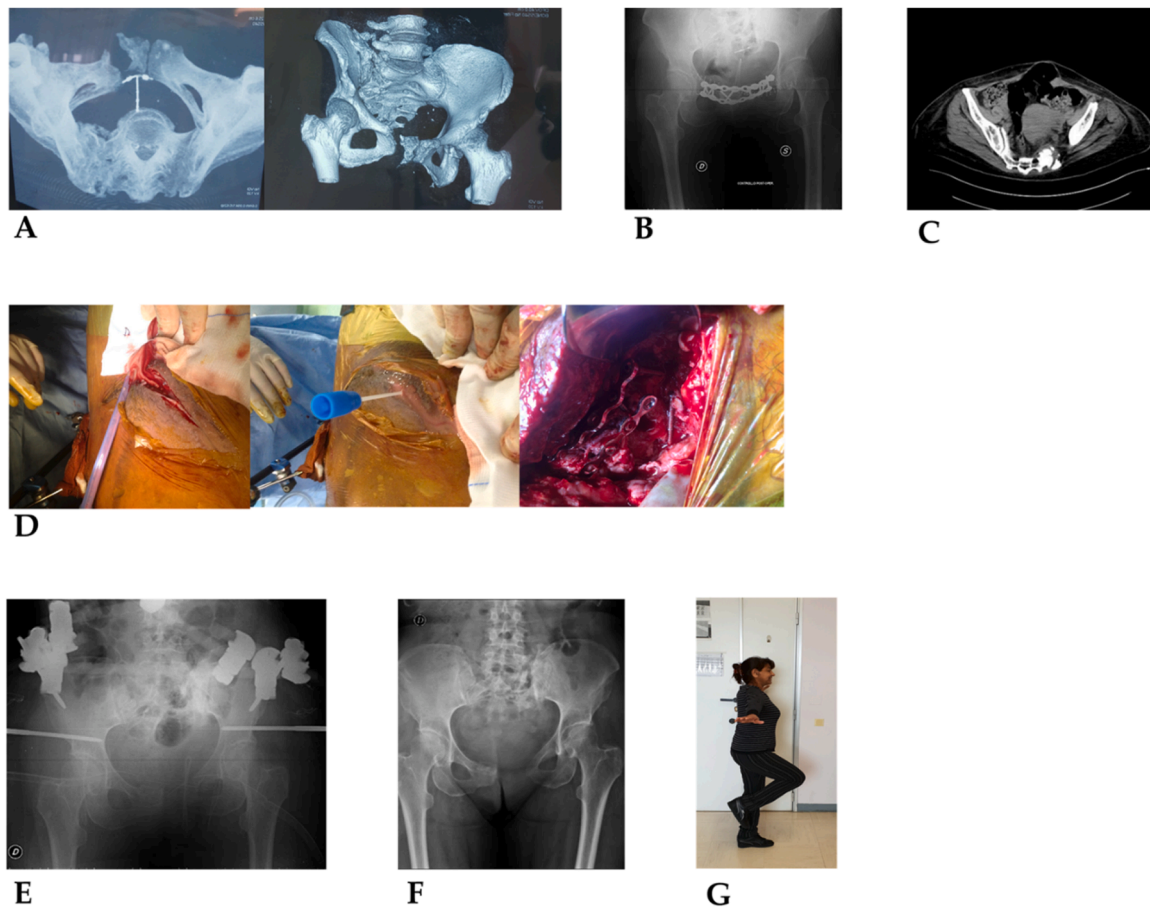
A: CT scan in the ED. B: Post-operative: plates and screws in open reduction and internal fixation. C: CT scan at 25 days due to pain and swelling with fistula: extensive purulent collection. D: Abundant pus, removal of fixation devices. E: Stabilization with EF, antibiotic therapy and HBOT. F: Follow-up X-ray and clinical examination at approximately 12 months. G: Clinical mobility of the leg.
